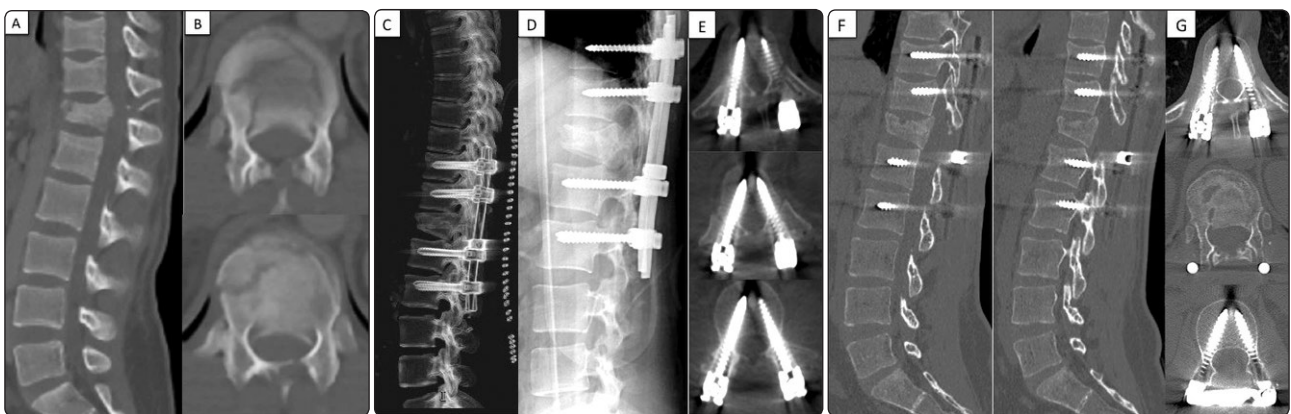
A 20-year-old male patient with D12 burst fracture after motorcar accident. Preoperative ASIA Grade E, VAS 9, and kyphotic angle 12°. Postoperative ASIA Grade E, VAS 2, and kyphotic angle 4°. Patient was operated upon via posterior transpedicular approach. (A,B) Sagittal and axial CT thoracolumbar spine showing D12 burst fracture with retropulsed fragment compressing the spinal canal. (C) Early postoperative 3 D CT thoracolumbar showing the screws in place. (D) Early postoperative X-ray lateral view showing well-positioned system. (E) Early postoperative CT scan axial cuts. (F,G) 6 months' postoperative CT sagittal and axial cuts.
